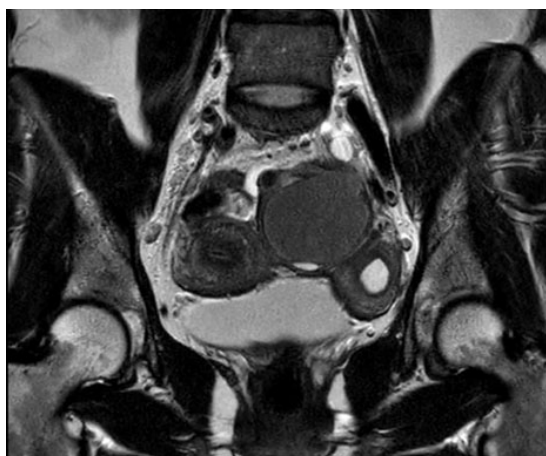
T2 MRI image of the two horns of the uterus with the left ovary endometrioma in between.
